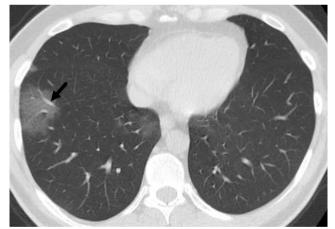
A 38-year-old female patient with a diagnosis of COVID-19 pneumonia. Chest CT image shows focal ground-glass opacities in the right lung and pulmonary vascular enlargement (also known as widened pulmonary vessel sign, arrow).
